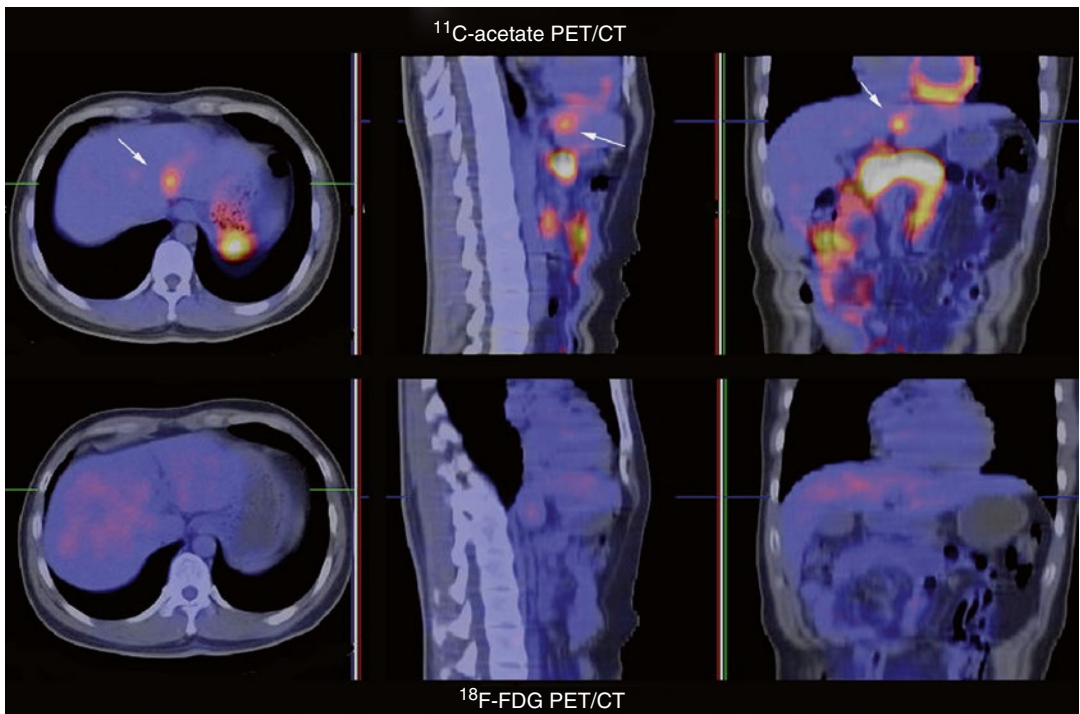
A small well-differentiated HCC (*arrows*), nodule size of 1,6 cm, shows increased ^{11}C -acetate metabolism (*upper row*) but is negative on ^{18}F -FDG (*lower row*) PET/CT
